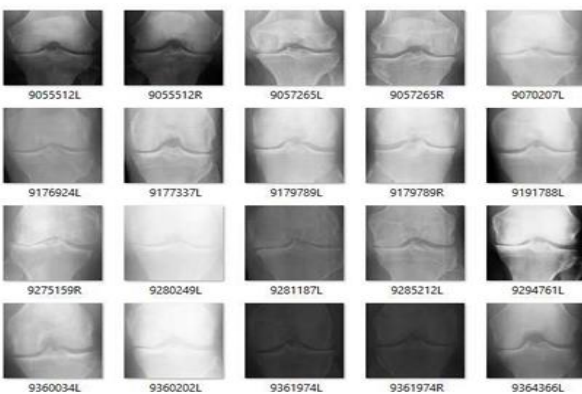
X-rays of Moderate
